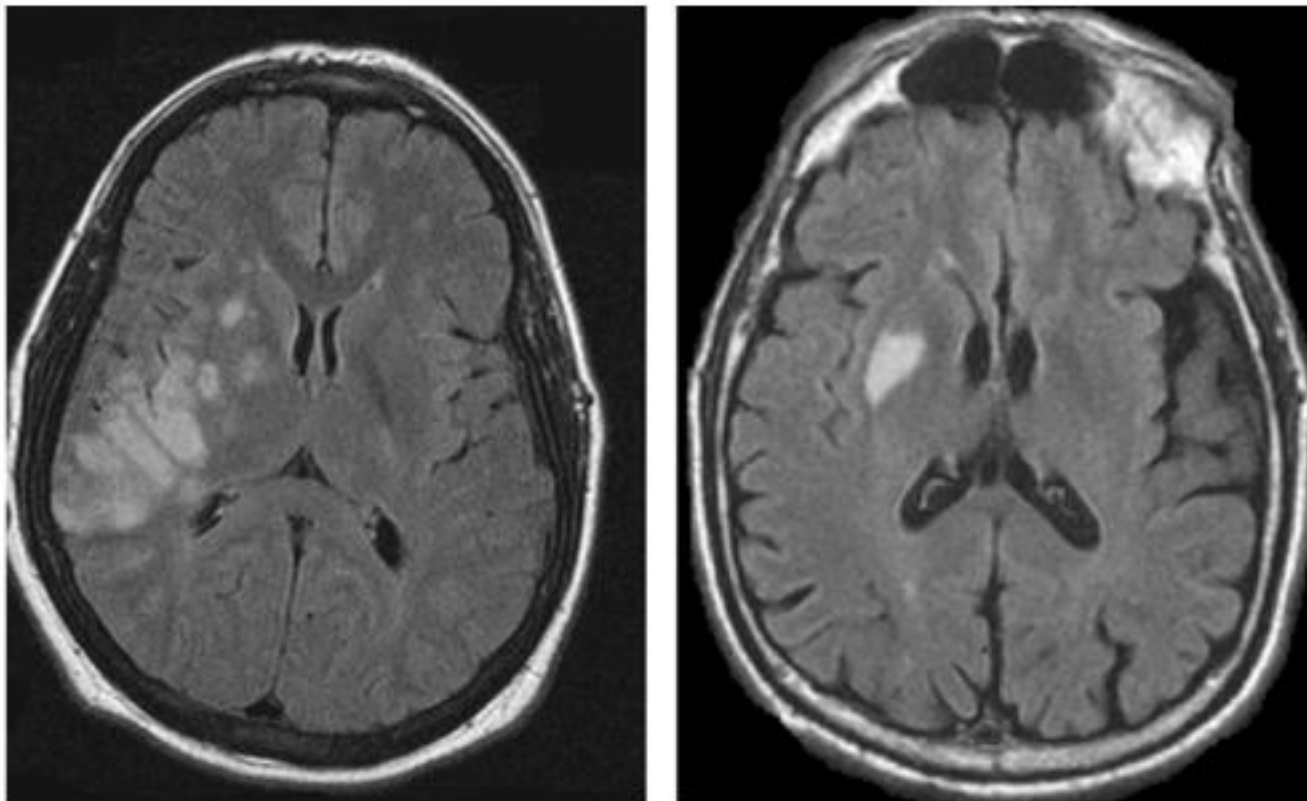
Hemiballism outside the STN. Left: an axial FLAIR T2 image in a 34-year-old man who presented with left-sided hemiballism, showing a large stroke in the right middle-cerebral-artery territory, which was later found to be secondary to endocarditis. There are several ischaemic areas in the basal ganglia and cortex. The region of the STN was spared. Right: an axial FLAIR T2 image in a 69-year-old man with a history of Parkinson's disease who presented with hemiballism of the left limb. An infarct is visible in the right striatum. The region of the STN was spared. This disorder was associated with improvement of the patient's parkinsonism on the left side. Similar improvement of parkinsonian features in association with hemiballism has been reported by many researchers, and these observations were part of the rationale for the development of STN deep brain stimulation in the treatment of Parkinson's disease.¹⁰
